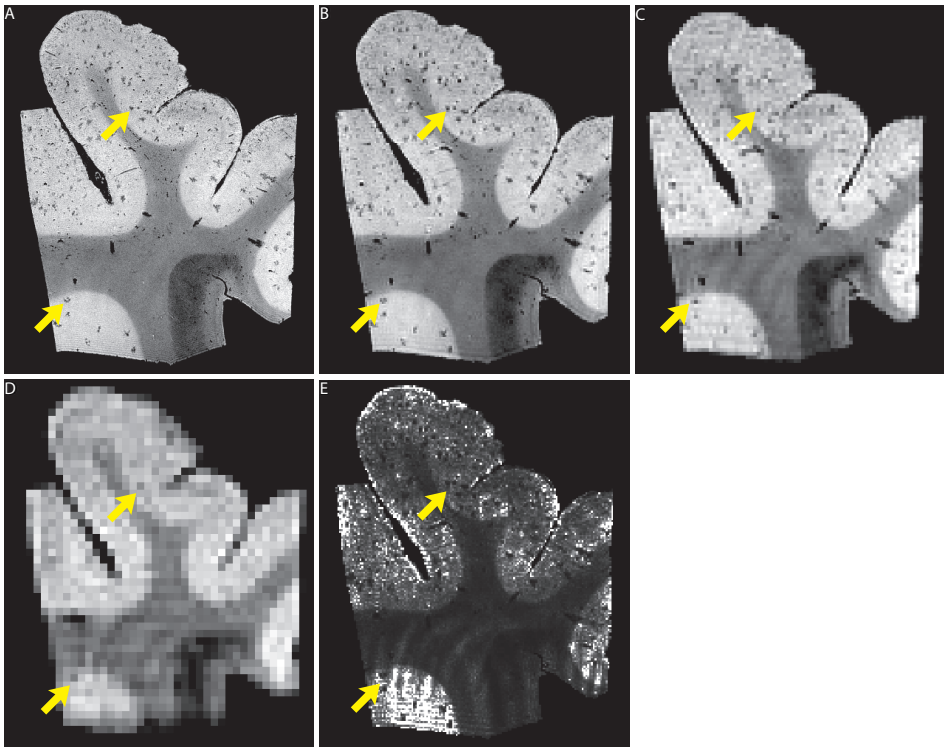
Hypo-intensities seen on MRI
